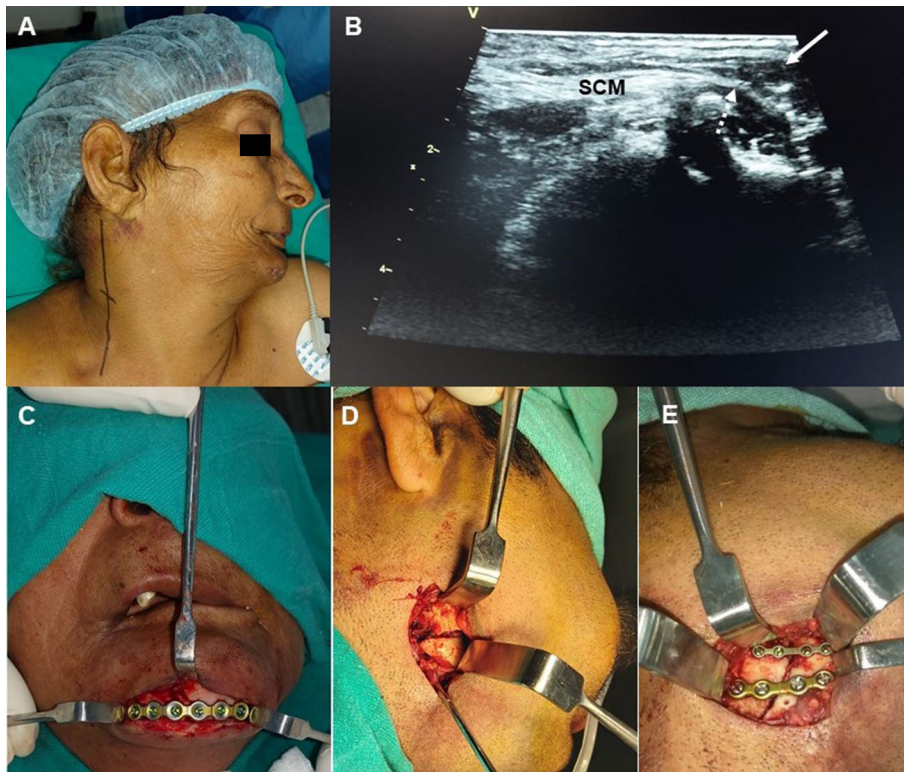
A Position and marking for superficial cervical plexus block B Ultrasonography appearance of the injection site. Broken arrow points to the posterior border of Sternocleidomastoid (SCM); Arrow points to the site insufflated after the injection of local anesthetic solution C Fixation of symphysis fracture of patient in A through an existing laceration; note that the patient underwent bilateral superficial cervical plexus block with bilateral mental nerve block with lingual infiltration D Displaced fracture of mandibular angle exposed using a submandibular incision with superficial cervical plexus block and extraoral mandibular nerve block vis sigmoid notch approach E Fixation of the fracture of mandibular angle as in D
